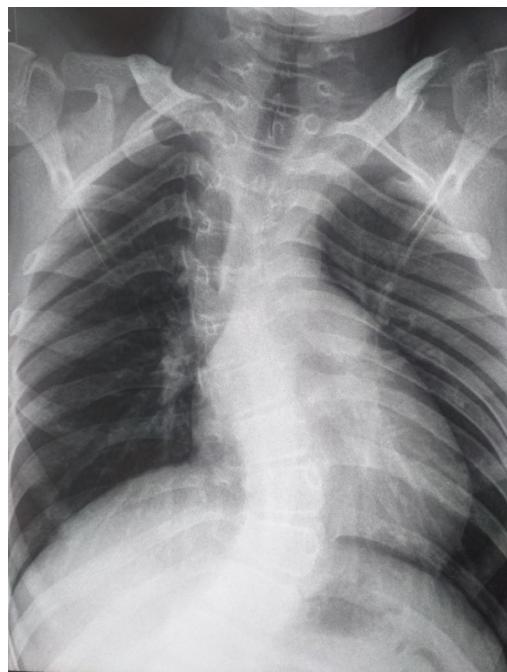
Chest X-ray at the age of ten years, showing the severe degree of scoliosis
